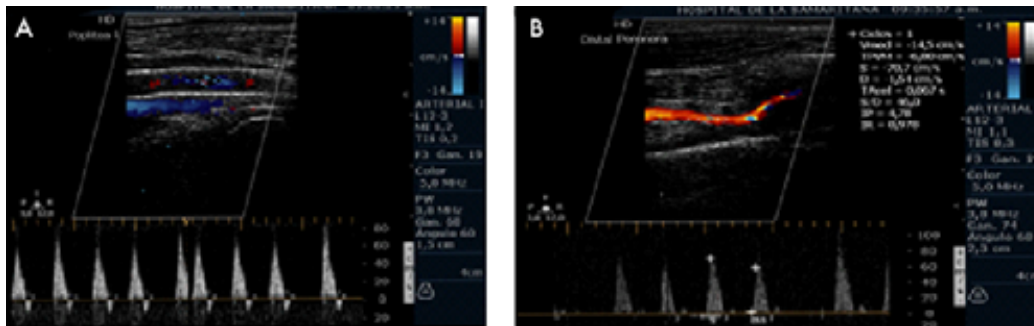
Follow-up duplex ultrasound 48 hours after ultrasound-guided mechanical thrombectomy, A) popliteal femoral artery stent patency, triphasic flow with no residual stenosis; B) distal peroneal artery run-off with evidence of triphasic flow.
